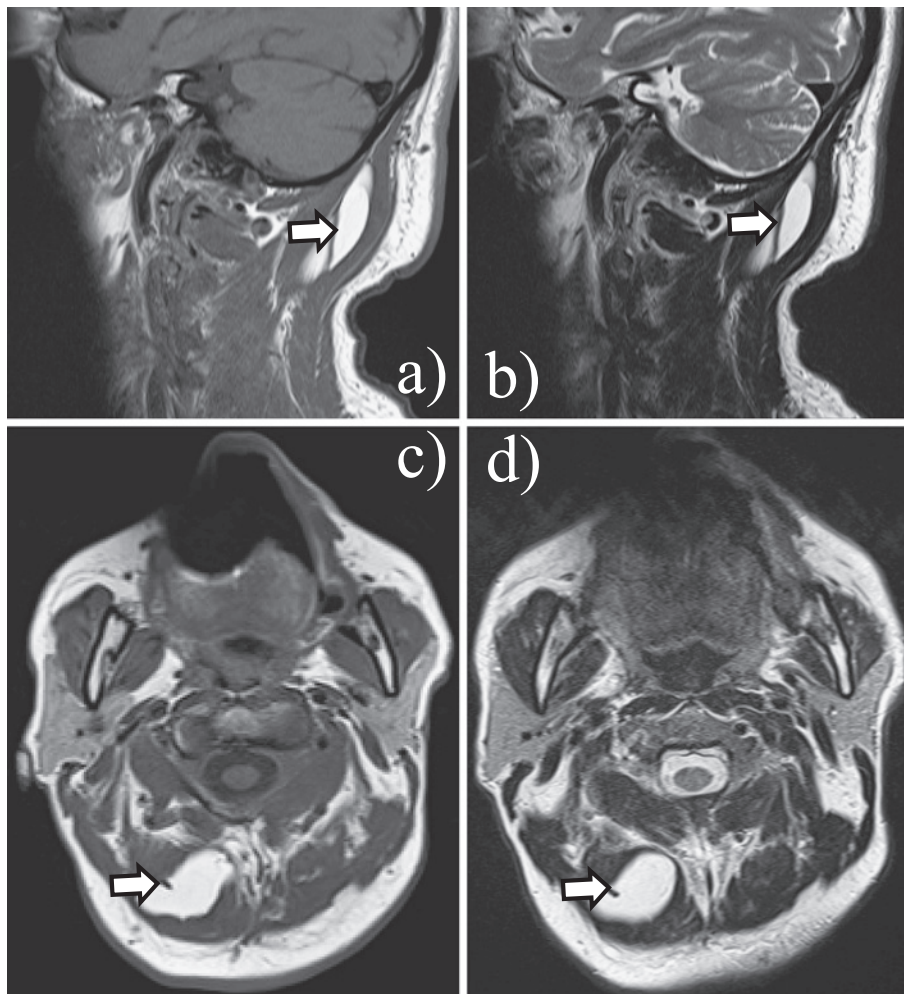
Cervical MRI images showing an intramuscular lipoma in the dorsal neck area. A band of muscle fibers (arrow) transects the lipoma. Sagittal T1-weighted (a) and T2-weighted images, and axial T1-weighted (c) and T2-weighted (d) images.
